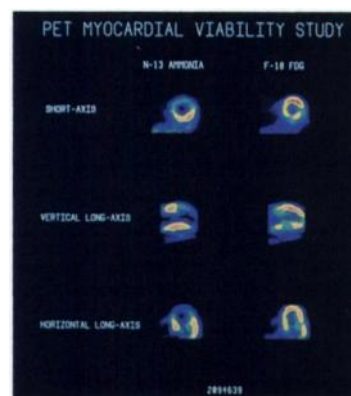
The presence of reduced resting perfusion as determined by ^{13}N -ammonia (left panels) accompanied by relatively increased FDG retention (right panels) in the anterior wall of this patient with prior infarction suggests the presence of ischemically jeopardized, but viable myocardium in the territory of an occluded left anterior descending artery.
